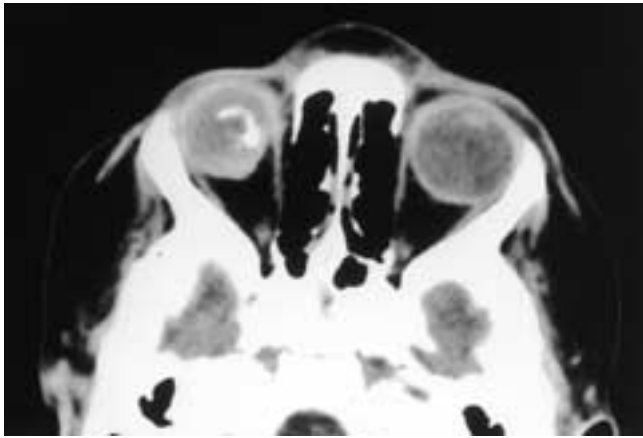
Phthisis bulbi: Axial CT scan shows a dense right eye with irregular calcification. This child with acquired immune deficiency syndrome developed cytomegalovirus chorioretinitis, resulting in a disorganized eye with associated dystrophic calcification.
